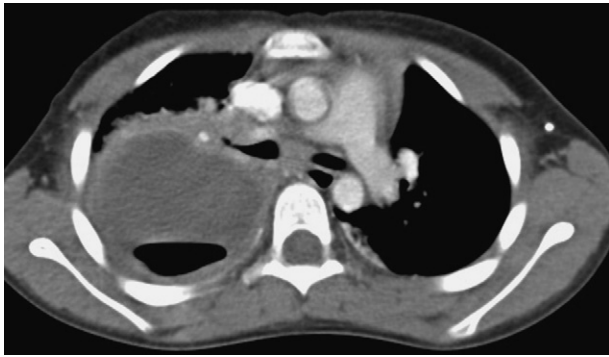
A computed tomography scan showing a lung abscess with a pigtail catheter inserted.
